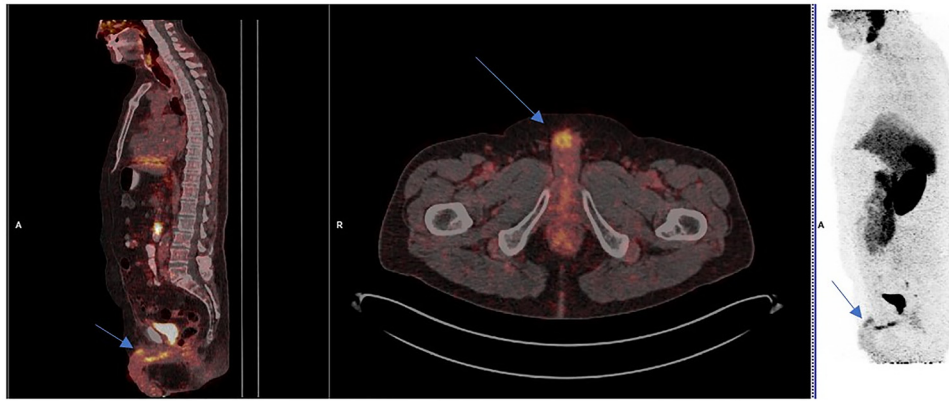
[^{68}Ga]Ga-PSMA-11 PET/CT sagittal, transversal fused images and maximum intensity projection (MIP) image showing pathological [^{68}Ga]Ga-PSMA-11 uptake in the root of the penis (SUVmax 7.9). The physiological urethral activity of [^{68}Ga]Ga-PSMA-11 is seen caudal of metastasis, usually occurring in patients with a history of TURP and can mask or mimic disease recurrence. (PET Hot body colour scale; threshold 0 – 10 SUV-bw)
